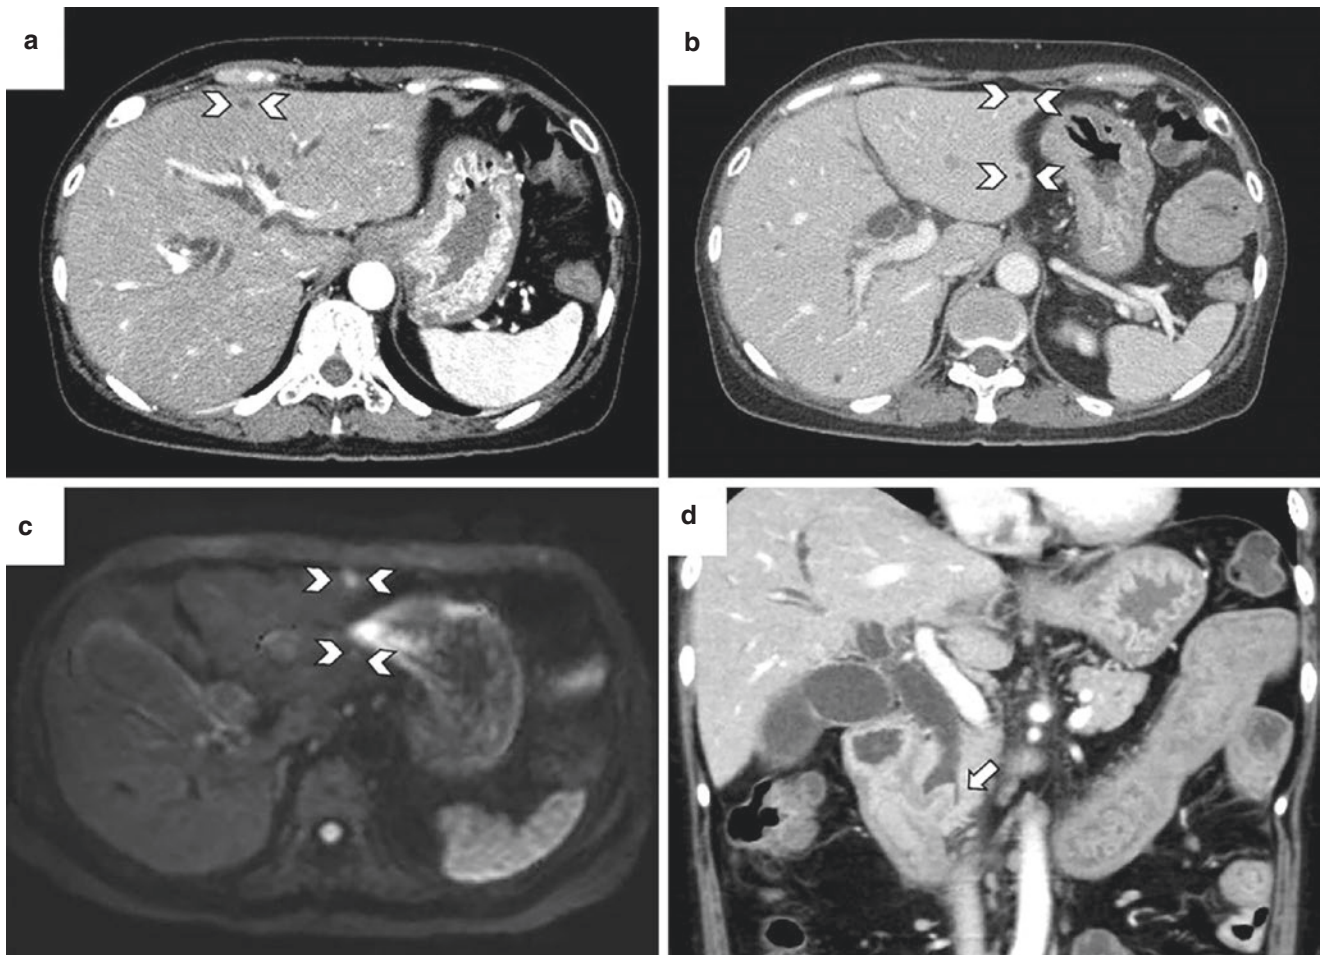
(a–e) Abdominal contrast-enhanced computed tomography (CT) and dynamic contrast-enhanced magnetic resonance imaging (MRI) findings. (a, b) CT showed the common bile duct dilatation and microabscesses in the left lobe of the liver (arrowhead). (c) Regarding MRI, the abscesses showed a positive signal on diffusion-weighted
